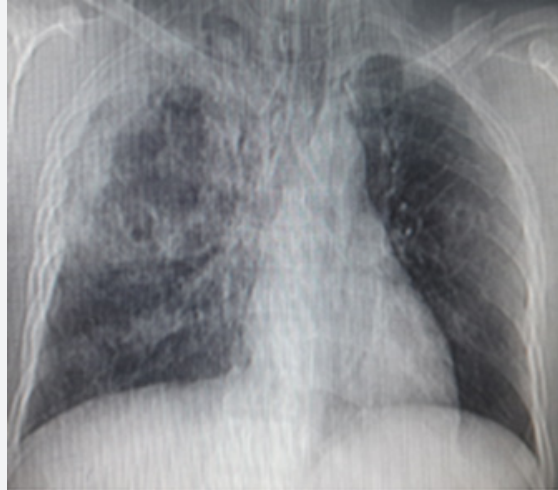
Plain radiograph of chest shows an ill-defined thick-walled cavity in right upper and middle zone, small cystic lesions in middle zones of both lungs and fracture in shaft of left clavicle.
